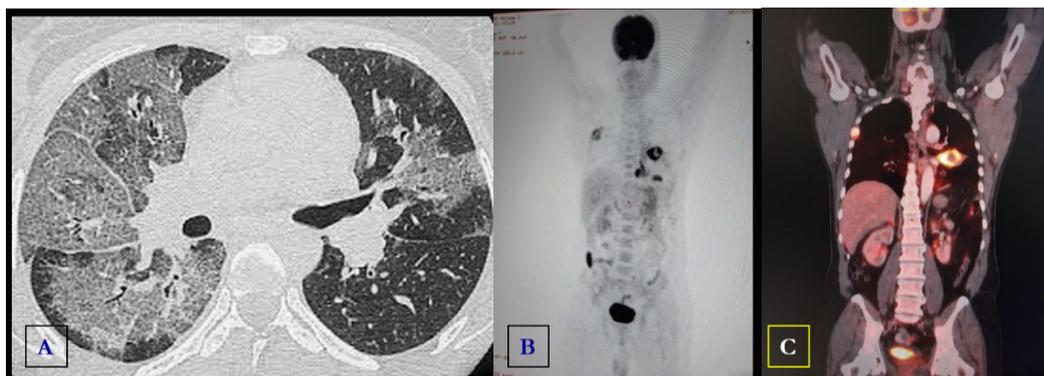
(A) CT Scan of chest showing inflammation in both lungs with ground glass opacity and discrete crazy-paving appearance associated with airspace consolidation, typical of COVID 19 infection. Bronchogenic growth also evident at left perihilar region. Three weeks later MIP (B) & fusion images (C) of PET-CT scan revealed hypermetabolic left perihilar and left paravertebral soft tissue mass compatible with cytologically proven malignant neoplastic lesion, hypermetabolic lesions in right 3rd & 4th ribs involving intercostal muscles, pericardium-signify metastases.
